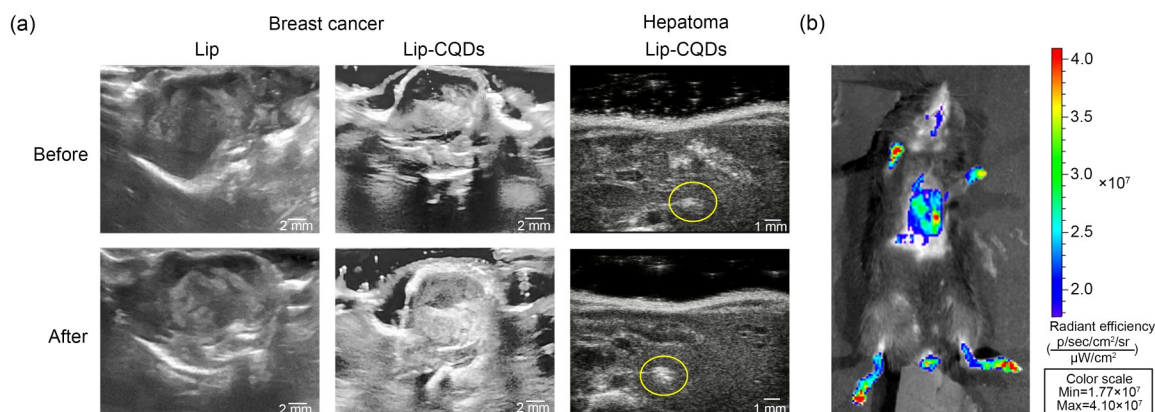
In vivo* imaging of Lip-CQDs. (a) *In vivo* ultrasound imaging results of Lip and Lip-CQDs; (b) *in vivo* fluorescence imaging of Lip-CQDs. Lip: liposome; CQDs: carbon quantum dots; Lip-CQDs: CQDs-loaded liposome.
